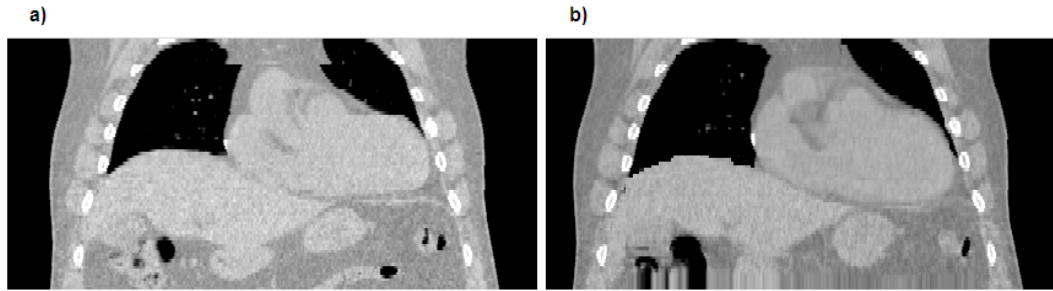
A coronal slice through frame 4 (mid-inhale) of the dataset of patient 2. a) The original CT frame and b) the transformed CT frame. An artefact affecting the superior portion of the heart can be seen in the original CT, which is not present in the transformed CT.
